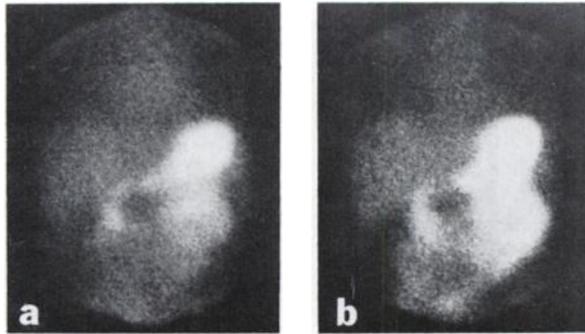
Negative scintigrams in a 4-year-old girl showing duodenal and jejunal activity at 20 min (a) and 50 min (b) after pertechnetate injection.
